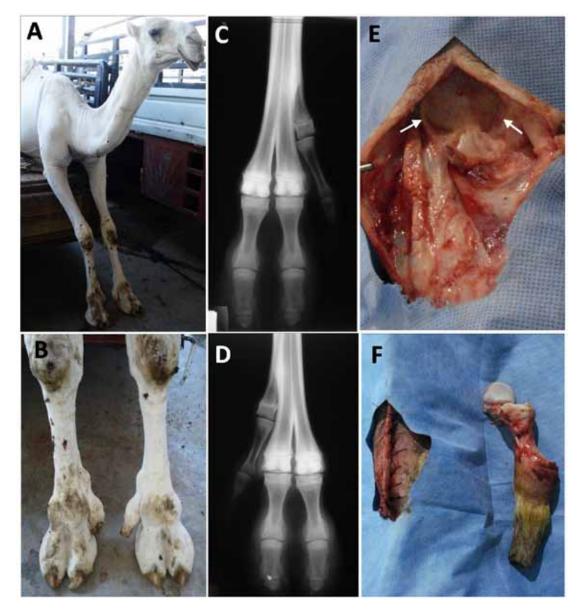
The heifer at the time of its presentation to the clinic with the two supernumerary digits (A), a close up picture of the forelimbs with the two supernumerary digit (B), dorsopalmar radiograph of the metacarpal region of the left (C) and right (D) forelimbs, intra-operative picture after osteotomy (E) note the cut end of the bone (arrows), the skin was closed with interrupted vertical mattress sutures and the amputated extra digit is seen beside the closed skin (F)
